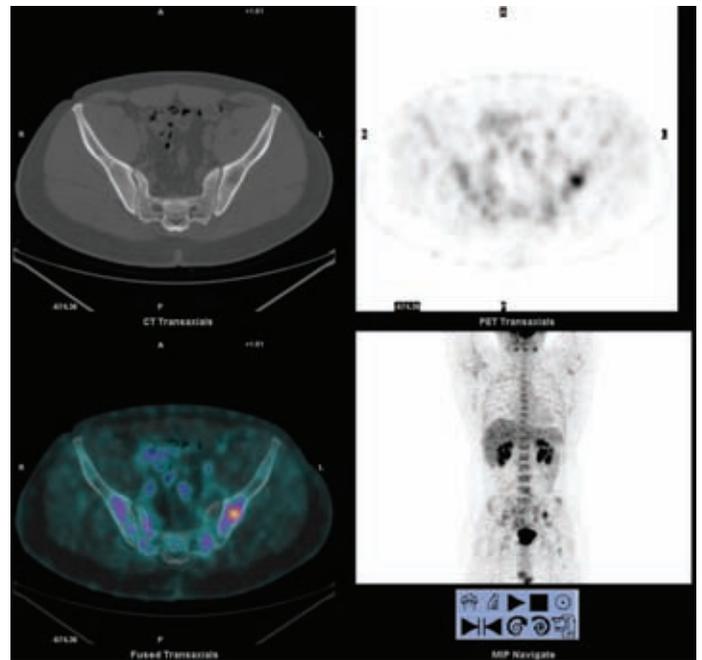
Positron Emission Tomography–Computed Tomography Four Weeks After the Initiation of Chemotherapy
